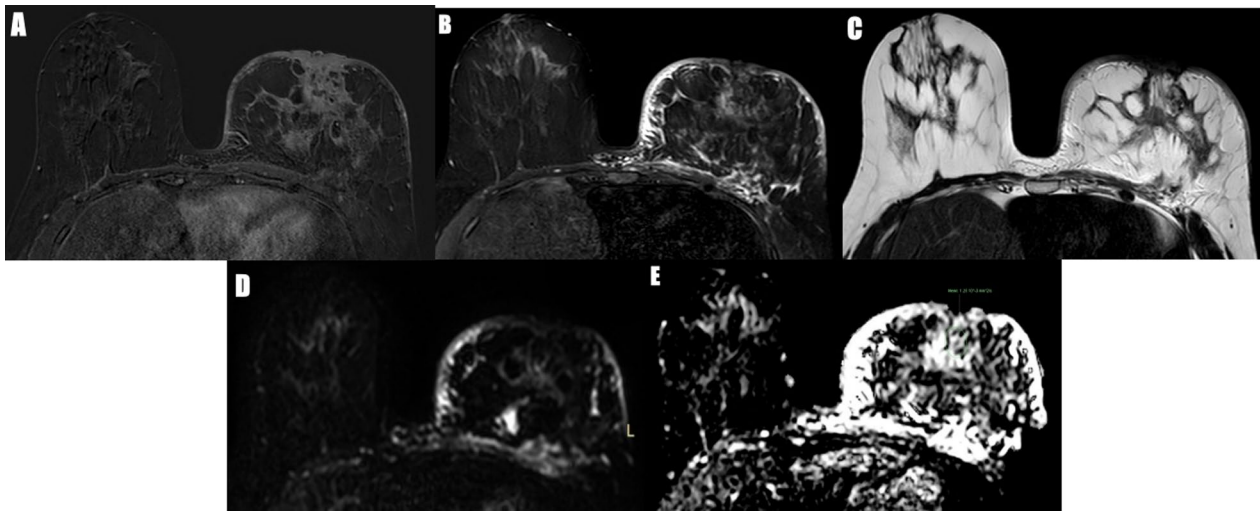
40-year-old female with a history of left breast ductal carcinoma in situ underwent left breast conservative surgery 3 months ago, and complained of acute left breast edema, ultrasound was done revealing edema with operative bed marked shadowing with no detected definite breast masses or axillary nodes. The patient was given antibiotic treatment for 2 weeks but with no response, then a post-contrast MRI was done and revealed: A Subtracted image: shows enhanced left breast skin and nipple associated with heterogeneous non-mass enhancement in the left retro areolar region extending to the posterior third. B STIR image: shows thickened edematous skin associated with underlying non-mass area of mixed low and intermediate SI. C T2WI image: shows thickened high SI skin associated with underlying non-mass area of mixed high and intermediate SI. D DWI: shows restricted diffusion of the skin of the left breast associated with underlying large non-mass that shows mainly free diffusion except in a small area of the posterior third. E ADC map: shows high ADC value = $1.25 \times 10^{-3} \text{ mm}^2/\text{s}$. Pathologically proved to be left breast grade II invasive ductal carcinoma, ER positive 7/8, PR positive 8/8, KI 67 15%, HER 2 positive 1. (STIR: short T1 inversion recovery, SI: signal intensity, WI: weighted imaging, DWI: diffusion weight imaging, ADC: apparent diffusion coefficient, ER: estrogen receptor, PR: progesterone receptor, HER2: human epidermal growth factor receptor 2)
